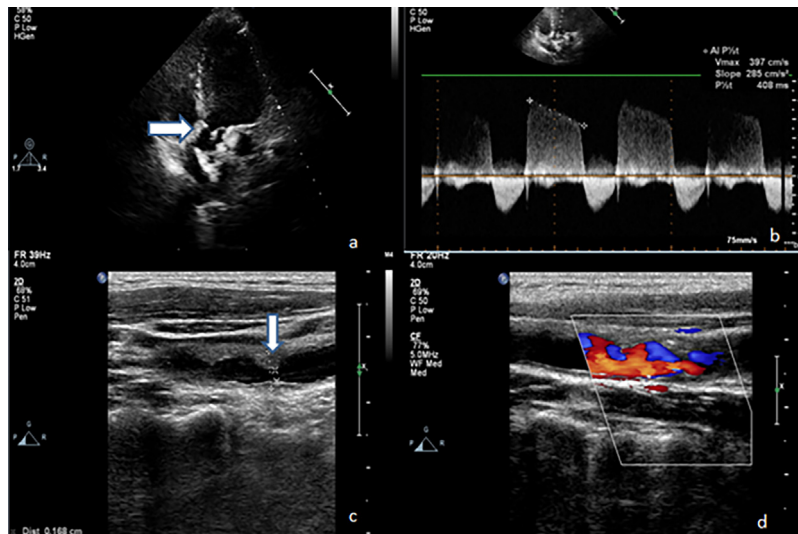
Echocardiogram showing thickened and calcified aortic valve and aortic root (a), mild aortic regurgitation (b), plaque (arrow) causing significant obstruction (c, d).
